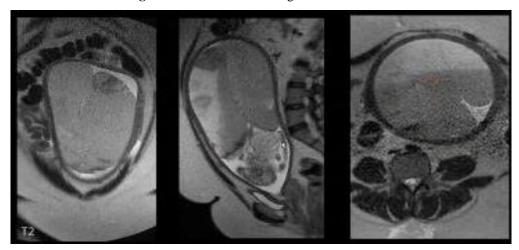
MRI showing Single Intrauterine Gestation with Crumpled Up Fetus in Transverse Lie with Central Opacities in Placenta
